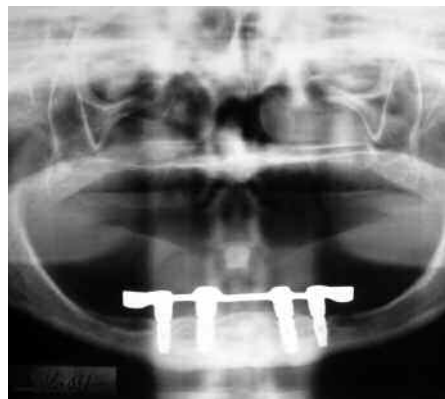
Panoramic radiograph demonstrating the presence of 4 mandibular implants and bilateral arthrosis of the TMJs.
